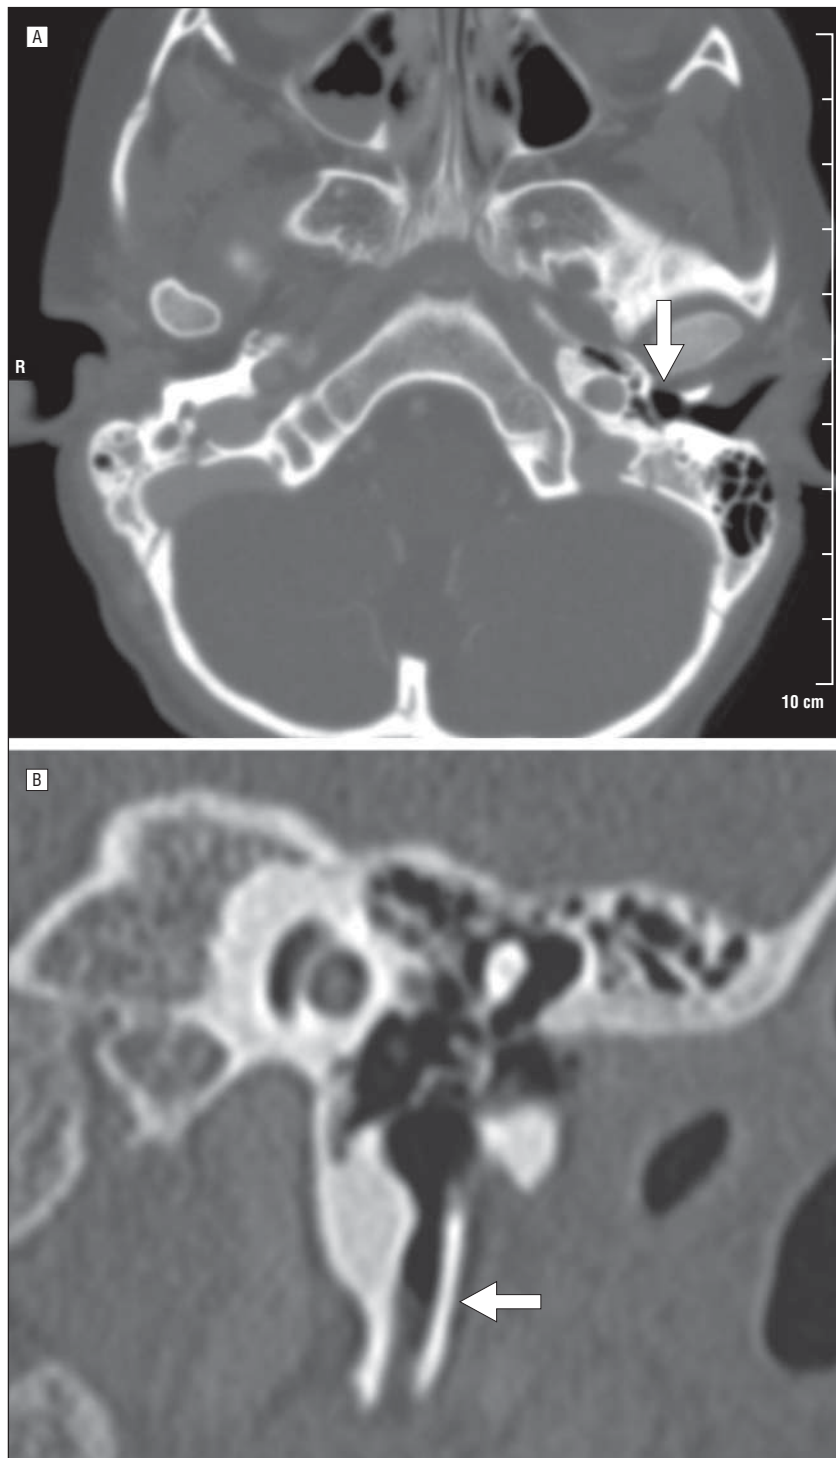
Case 1. A postcontrast computed tomogram depicting an anteroinferior external auditory canal defect (A, arrow) and a coronal cut showing a dysmorphic styloid process (B, arrow).
